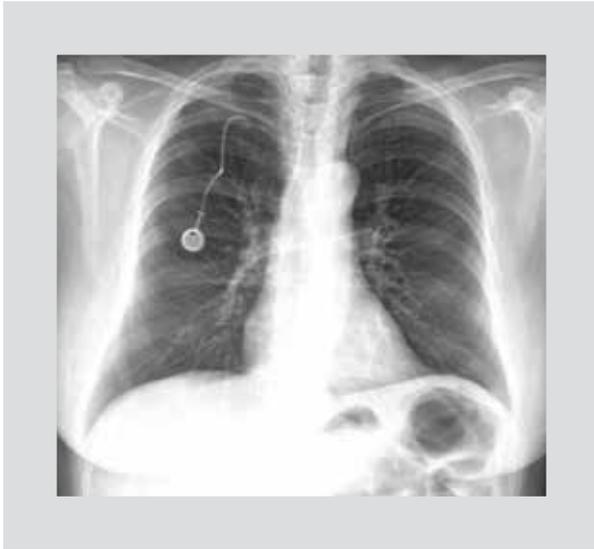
Posteroanterior chest x-ray where the catheter occupying the right and left pulmonary branches and the pulmonary trunk is observed.
